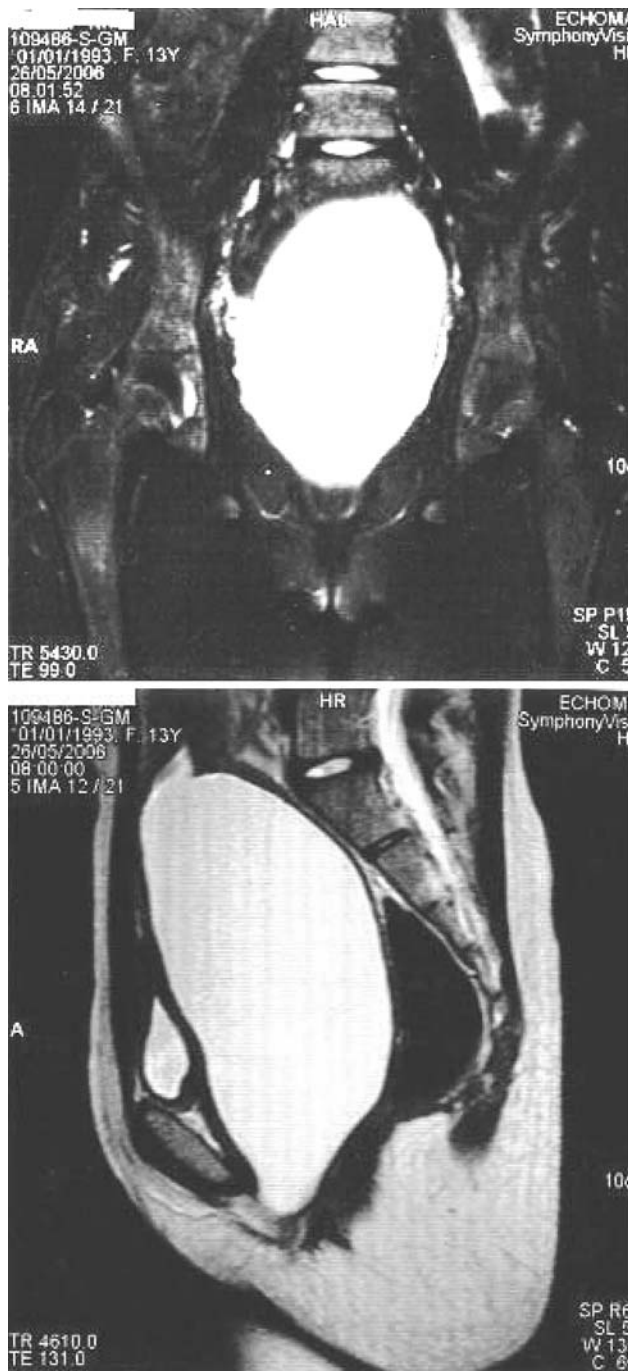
Coronal and sagittal section of MRI view of hydrometrocolpos
